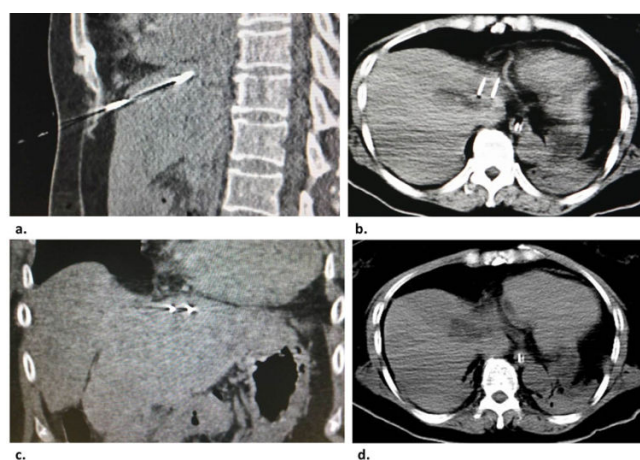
Intraoperative CT images of the patient a: sagittal plane; b: cross-section; c: coronal plane; d: cross-section of immediately after IRE ablation.
